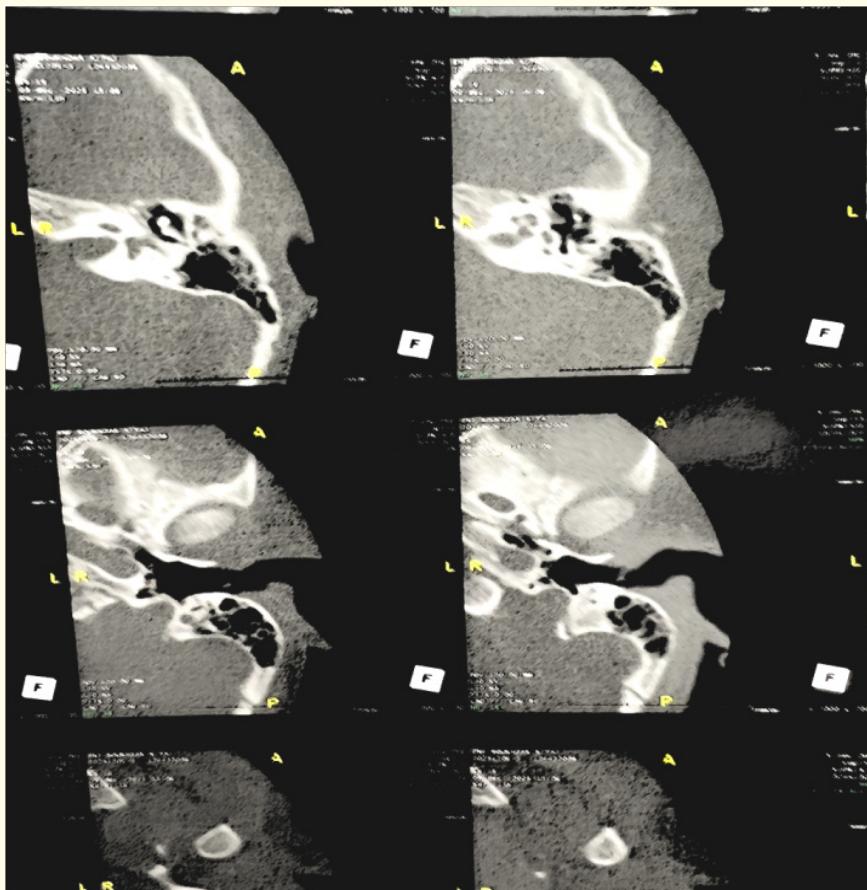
Computed tomography of the left temporal bone. Axial reconstruction showing agenesis of the stapes.
